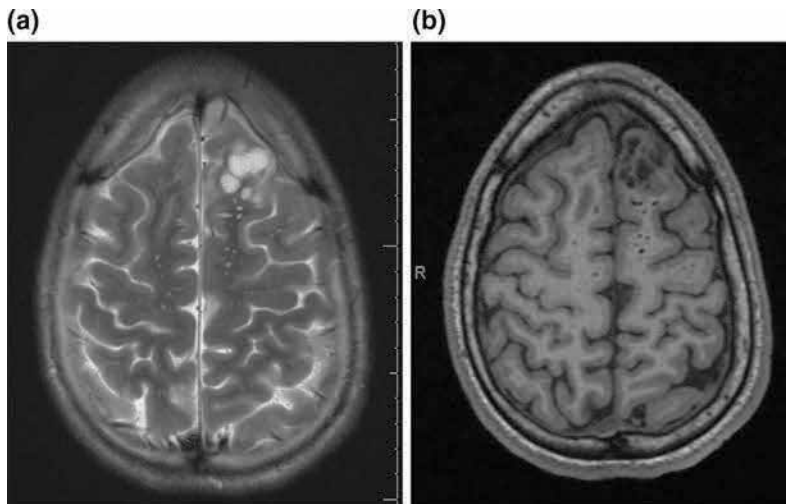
Axial T2- and T1-weighted MRI (a and b) demonstrate bubbly T2 bright lesion in the left superior frontal gyrus with minimal mass effect that does not enhance (contrast not shown). In a patient with seizures, these findings are most consistent with dysembryoplastic neuroepithelial tumor (DNET).
